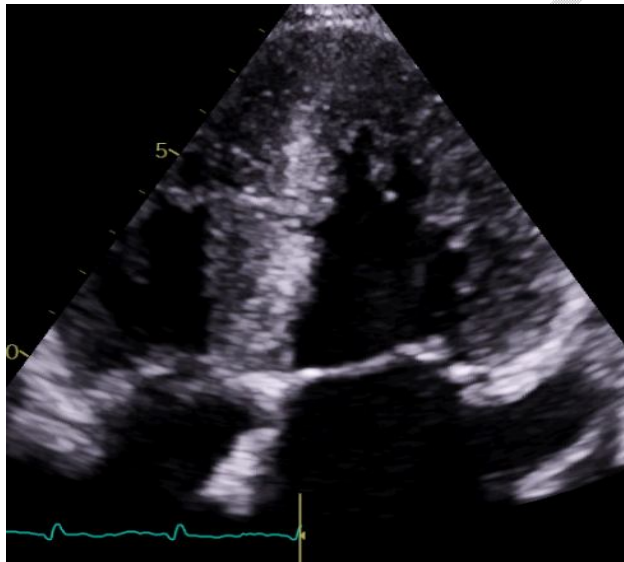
Trans thoracic echocardiography: 4 chambers apical view: showing a hypertrophic left ventricle with a septal wall thickness of 18mm.
